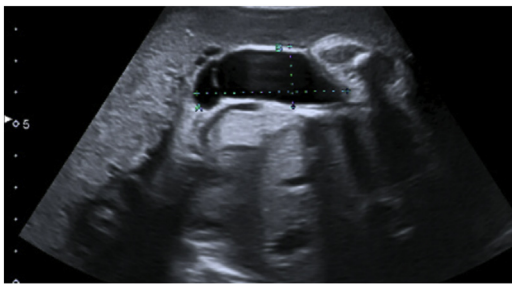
Sonographic appearance of fetal chest wall cystic lymphangioma at 32 weeks of gestation (Case 1).
